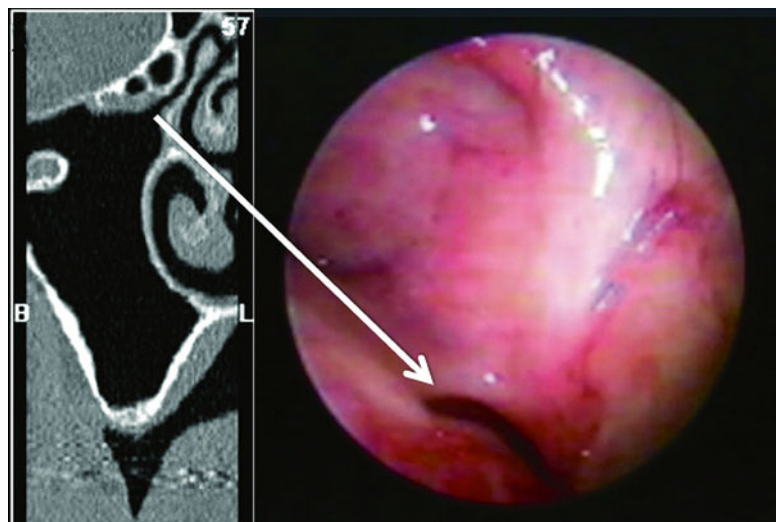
Computed tomography scan 3D view of the lateral wall of the maxillary sinus which shows the point of emergence of the infraorbital artery (IOA) and the point
